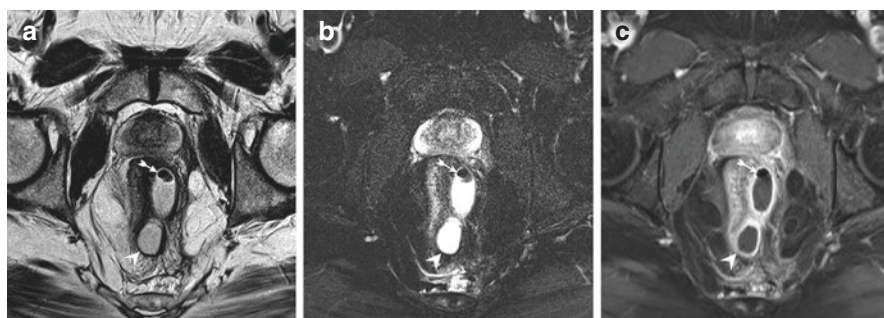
An abscess (arrowhead) on axial oblique sequences: relatively hyperintense on a T2-weighted sequence (a), hyperintense on a T2-weighted sequence with fat suppression (b), and rim enhancement (i.e., granulation tissue) with a hypointense content (i.e., fluid) on a T1-weighted post-contrast sequence (c). On every sequence gas is visible anteriorly as a hypointense area in the abscess (tailed arrow)
